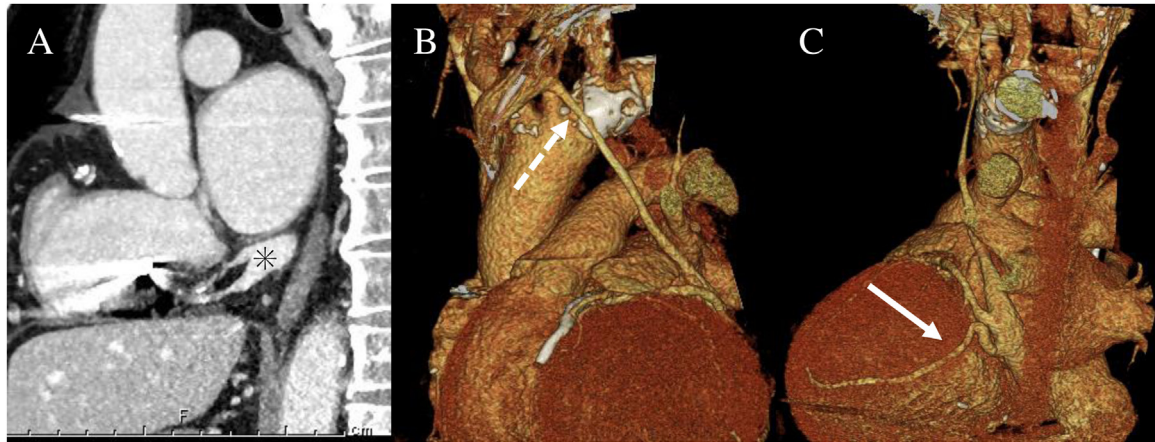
The coronary sinus ostial atresia and persistent left superior vena cava on contrast-enhanced computed tomography, sagittal plane (A), anterior view (B), and posterolateral view (C) of the three-dimensional image. They show membranous occlusion of the coronary sinus at the ostium (asterisk), the persistent left superior vena cava with a small diameter, approximately 3.5 mm (dashed arrow), and the target lateral vein (solid arrow).
